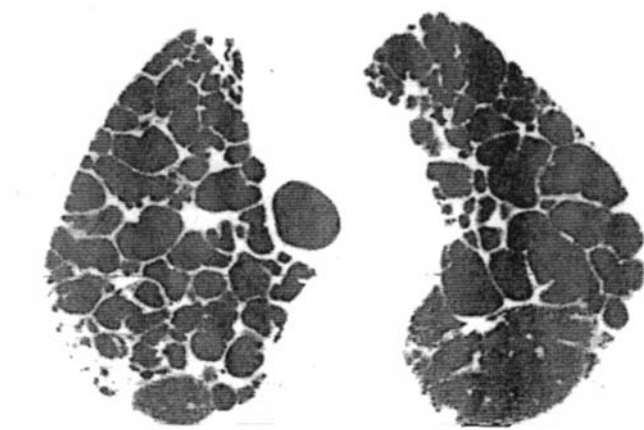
Advanced fibrocystic sarcoidosis. HRCT lobes (apices) demonstrate nearly complete replacement of lung parenchyma by cysts. The upper lobe predominance is typical of sarcoidosis.
